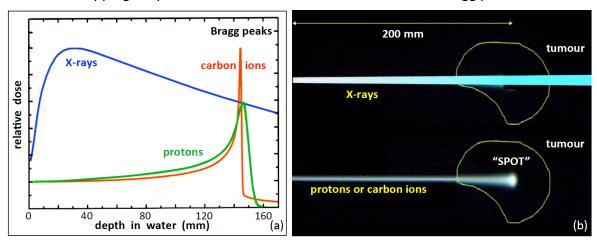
(a) The dose distributions due to beams of X-rays, protons and carbon ions are very different because of the Bragg peaks. (b) In water (and also in soft tissues) the spot is at a depth of 200 mm when the energies of the protons and carbon ions are 170 MeV and 4000 MeV respectively. (In the carbon case a small 'tail', due to nuclear fragments, follows the spot but is not shown.)
